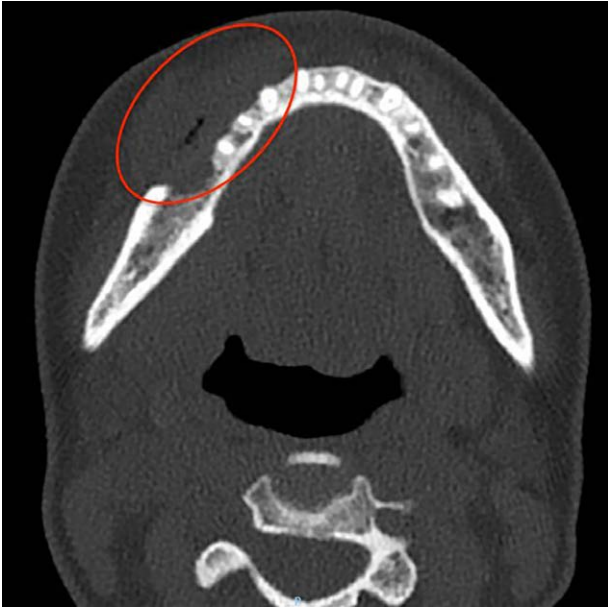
Presurgery computed tomography. Red circles mark the mass. The tumoral mass eroded the right jawbone.
